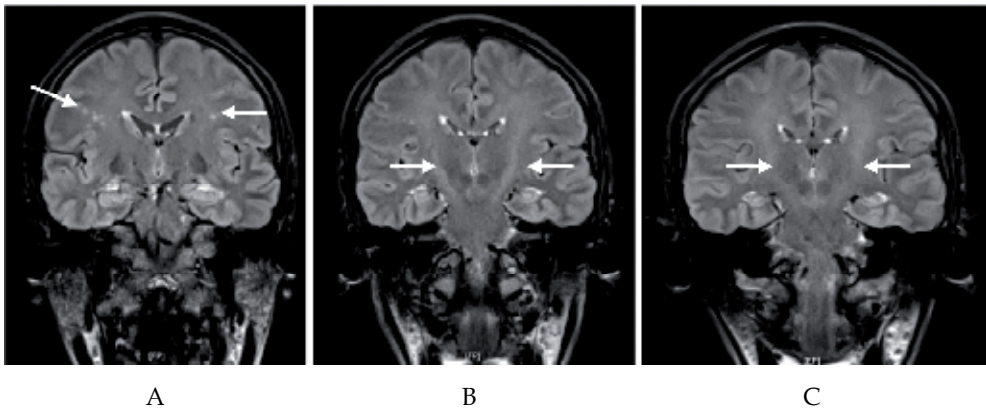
Coronal FLAIR images of a cirrhotic patient A to C. Coronal FLAIR images show the areas with abnormal high signal intensity in or around the corticospinal tract (arrows).
